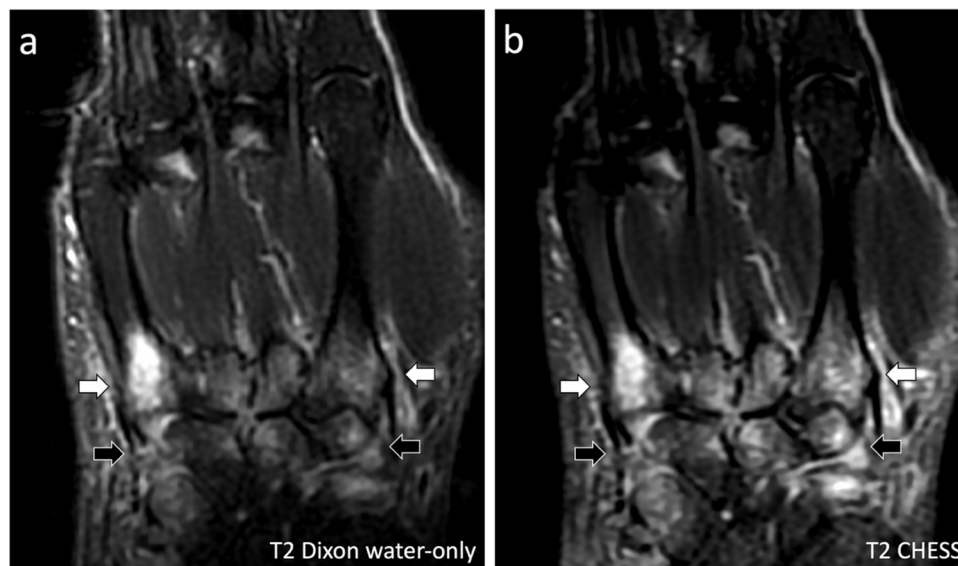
Similar appearance of carpal (black arrows) and metacarpal (white arrows) bones osteitis on coronal SE T2-weighted (a) Dixon water-only and (b) CHESSE focused images of a 56-year-old man with early RA.
